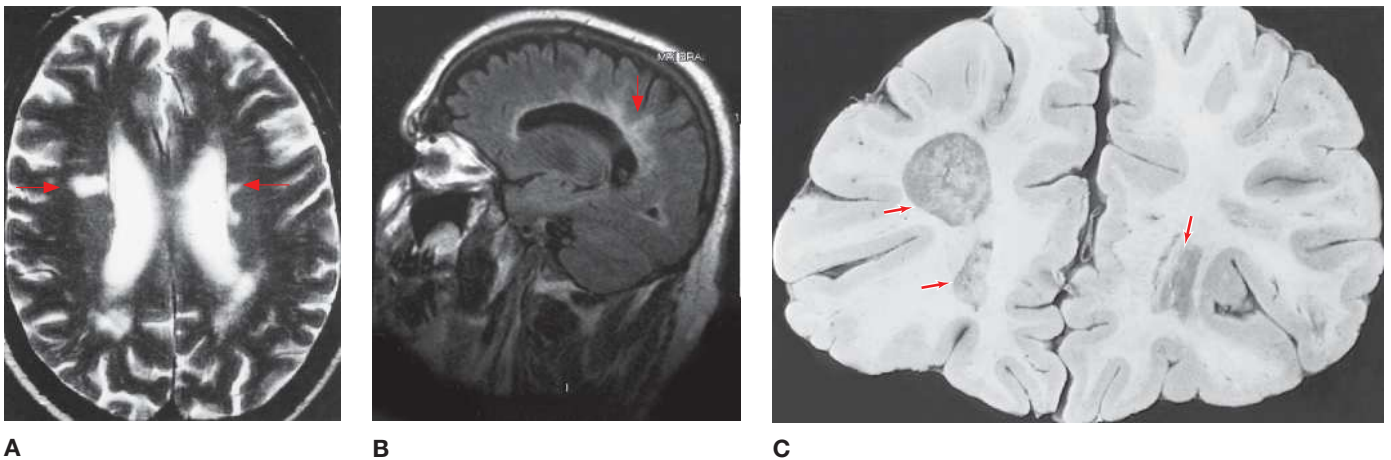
Multiple sclerosis. Transaxial T2-weighted MRI (A) and sagittal FLAIR image (B) showing multiple MS plaques (arrows) in the periventricular matter oriented radially from the corpus callosum (“Dawson fingers”). (C) Areas of demyelination of the white matter (arrows) in the frontal lobe of a patient with multiple sclerosis. (Images A and B reproduced with permission from Ropper AH, Samuels MA. *Adams & Victor’s Principles of Neurology*, 9th ed. New York: McGraw-Hill, 2009, Fig. 36-1. Image C reproduced with permission from Waxman SG. *Clinical Neuroanatomy*, 27th ed. New York: McGraw-Hill, 2013, Fig. 25-9.)
